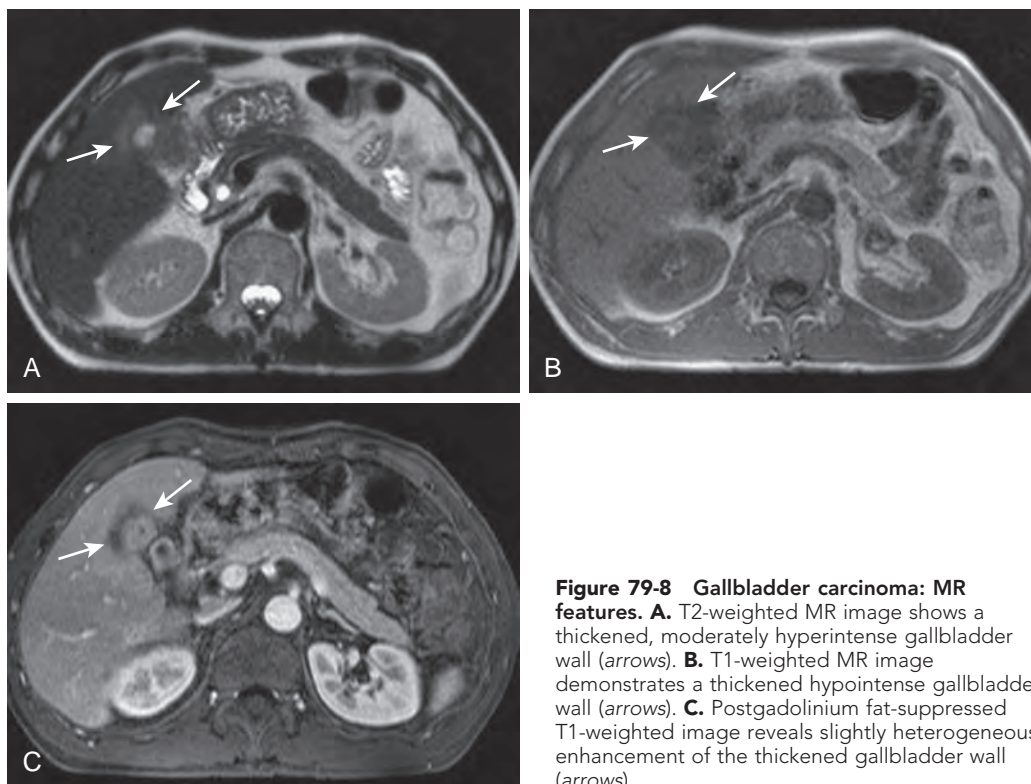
Gallbladder carcinoma: MR features. A. T2-weighted MR image shows a thickened, moderately hyperintense gallbladder wall (arrows). B. T1-weighted MR image demonstrates a thickened hypointense gallbladder wall (arrows). C. Postgadolinium fat-suppressed T1-weighted image reveals slightly heterogeneous enhancement of the thickened gallbladder wall (arrows).
